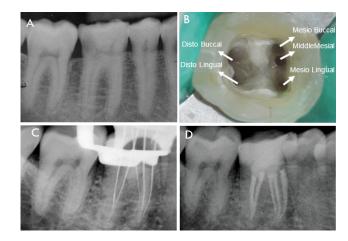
A: Preoperative Radiograph, B: Five Canal Orifices, C: Working Length, D: Post-operative Radiograph.
